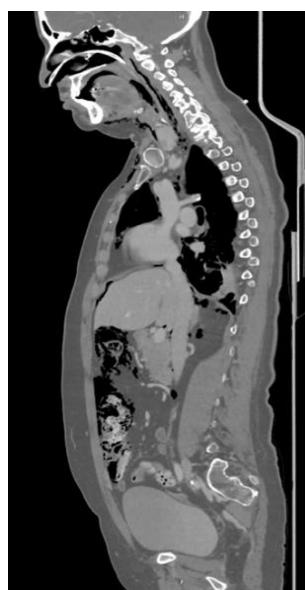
Sagittal planne of the CT scan, where it is revealed pneumomediastinum, pneumoperitoneum, and pneumatization of the colon wall.
